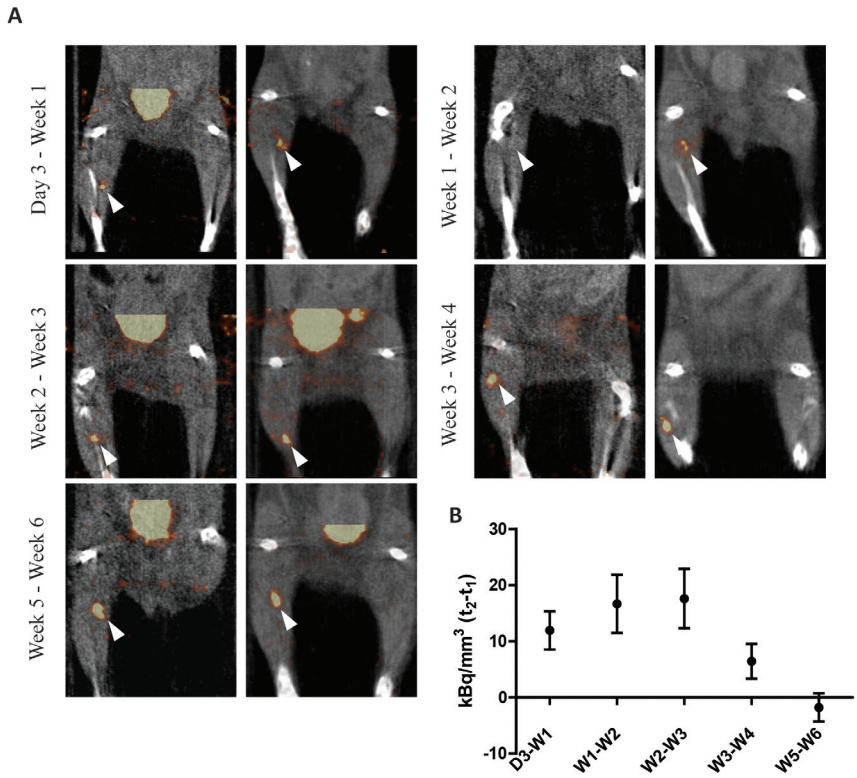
In-vivo detection of pancreatic islets at different weeks. (A) Representative images from *in-vivo* scans at two different time-points with one week interval. Transplants are indicated with white arrows. (B) SPECT quantitative analysis where t_2-t_1 corresponds to 7 days interval between both scans shows improved uptake of ^{111}In -exendin-3 and first signs of stabilization of tracer uptake between 3 weeks and 4 weeks post-transplantation.
